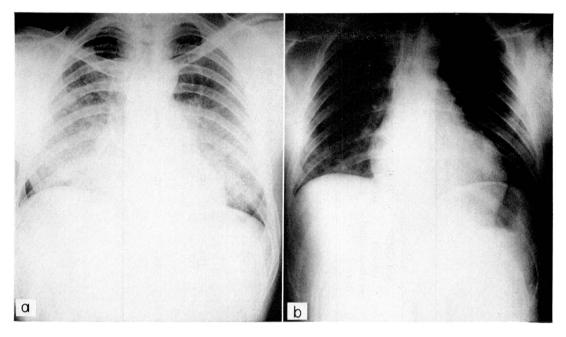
R.McG.'s chest radiographs, (a) before treatment, and (b) after 3 days plasma exchange alone.
